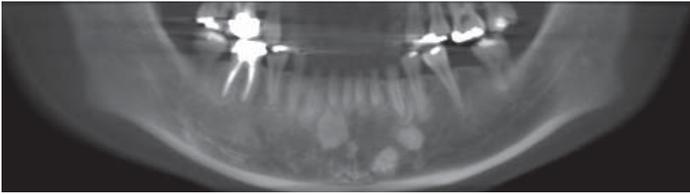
Panoramic radiograph showing the radiopacity in the right mandible.
